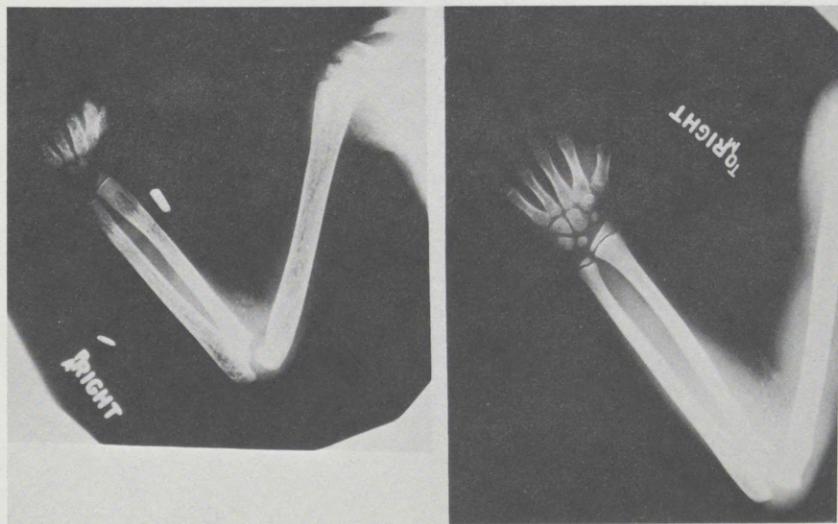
Roentgenograms of the right arm of child with homozygous beta thalassemia. Note growth and recalcification after transfusion therapy.
